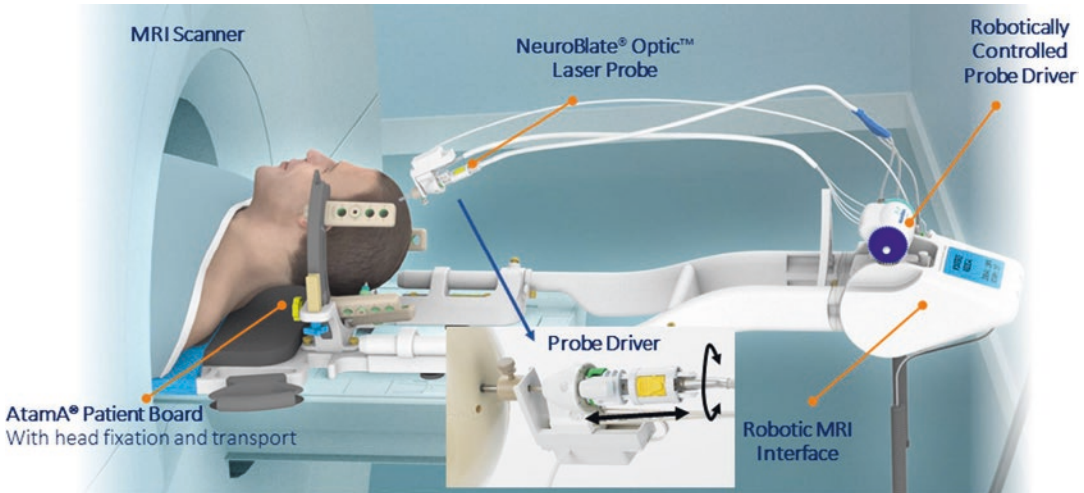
The NeuroBlate system shown within the MRI with the robotic probe driver affixed to the Mini-Bolt and the laser delivery probe inserted via probe driver. (Used with permission. © 2019 Monteris Medical)
